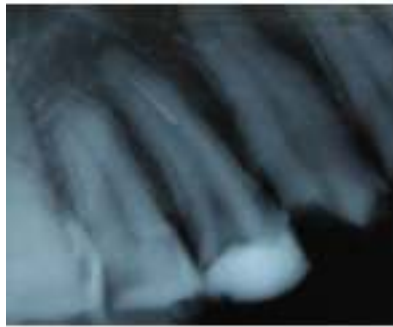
Radiographic confirmation of the fractured
